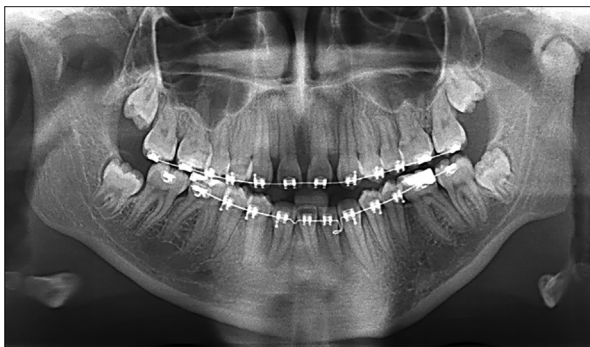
Panoramic radiograph for control of root parallelism during the finishing stage.
